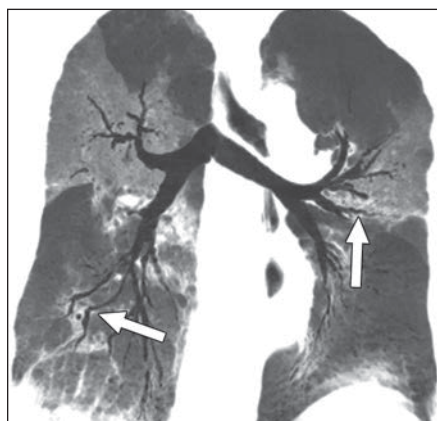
66-year-old man with coronavirus disease (COVID-19). Minimum-intensity-projection CT image shows bronchus deformation due to fibrosis and striplike lesions (arrows).
